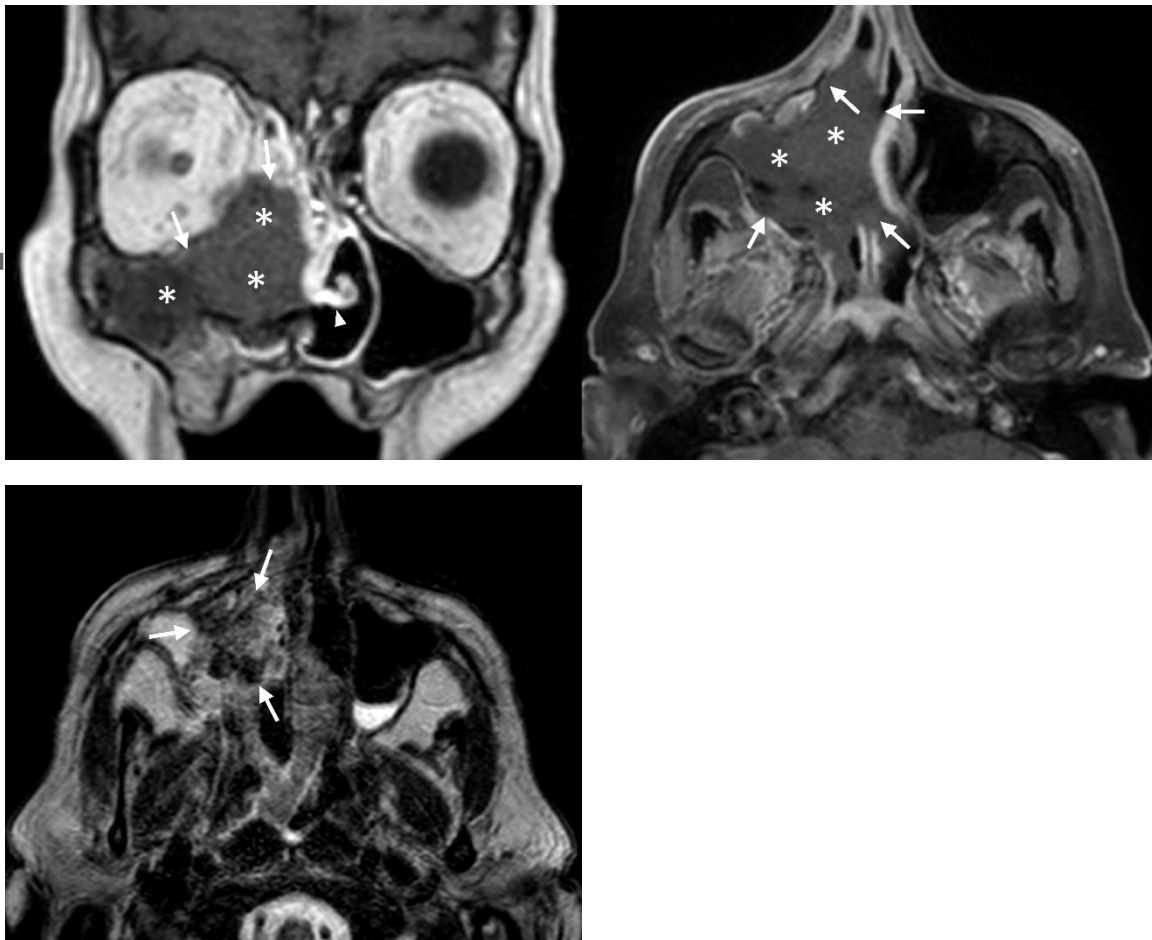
61-year-old male with invasive fungal rhinosinusitis. Contrast-enhanced T1-weighted image (A, B) shows a non-enhancing lesion (*) from the right maxillary sinus to the nasal cavity and lack of contrast enhancement of the adjacent right maxillary sinus and nasal mucosa and nasal septum (arrows). The normal nasal turbinate (arrowhead) is absent on the right side (black turbinate sign). T2-weighted image (C) shows heterogeneous low-signal intensity (arrows) within the lesion.
